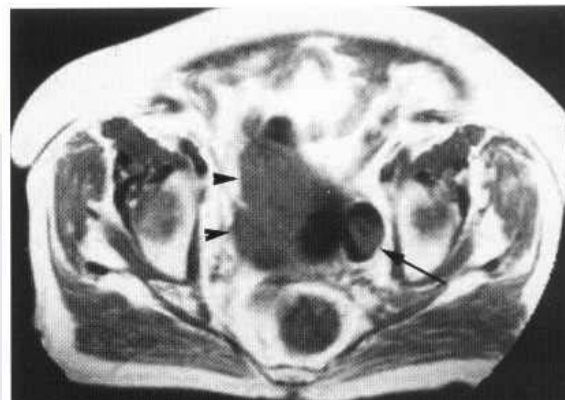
T₁-weighted MRI showing a large right-sided bladder carcinoma (arrowheads) and a small left-sided diverticulum (arrow) containing a further deposit of carcinoma.
